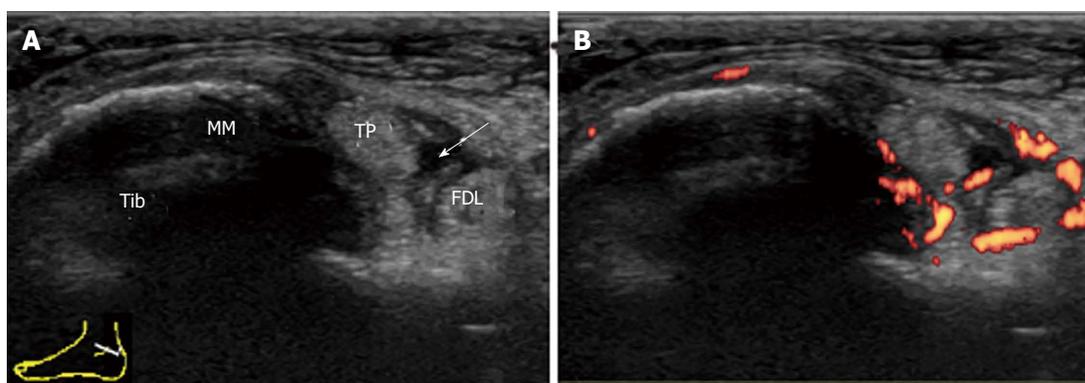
Proliferative tenosynovitis of the tibialis posterior in rheumatoid arthritis. A: Transverse grey-scale sonogram through the medial ankle at the level of the medial malleolus (MM). Hypoechoic thickened tenosynovium of the TP with anechoic effusion (arrow) within the sheath is depicted; B: Power Doppler sonogram shows hyperemia of the tenosynovium surrounding the TP and the FDL. Tib: Tibia; TP: Tibialis posterior; MM: Medial malleolus; FDL: Flexor digitorum longus.
